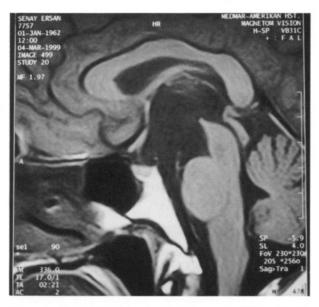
A sagittal T1-weighted image (TR/TE=460/15 ms) shows enlargement of the suprasellar cistern and displacement of the optic chiasm.
